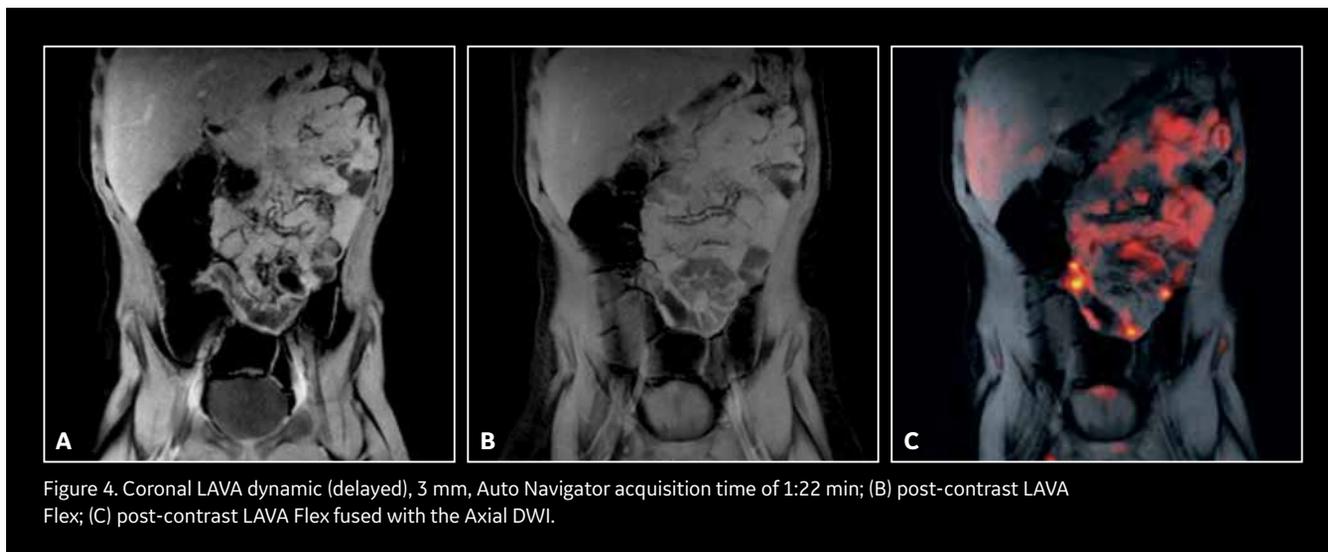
Coronal LAVA dynamic (delayed), 3 mm, Auto Navigator acquisition time of 1:22 min; (B) post-contrast LAVA Flex; (C) post-contrast LAVA Flex fused with the Axial DWI.
